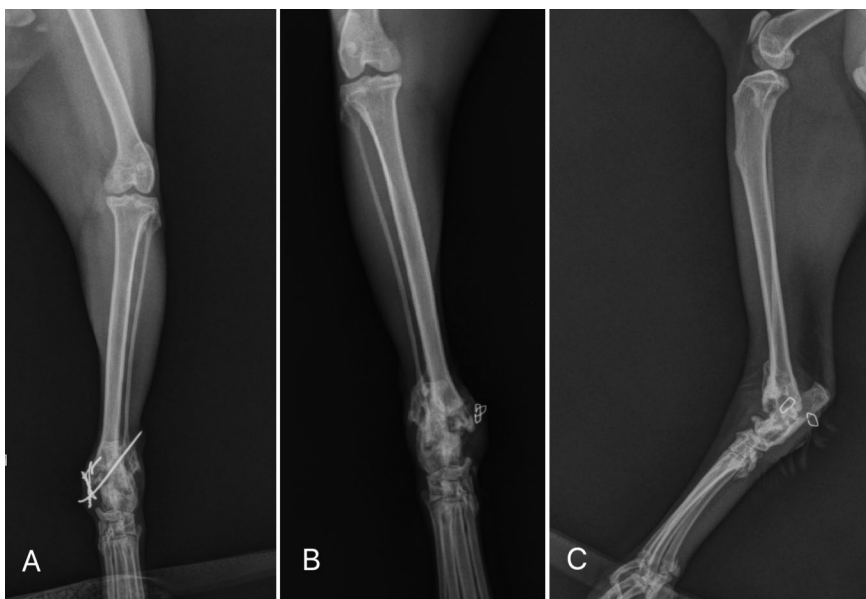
Follow-up radiographs after eight weeks, before Kirschner pin and tension band were removed (A). Moderate callus formation seen on dorsoplantar (B) and medial view (C)
